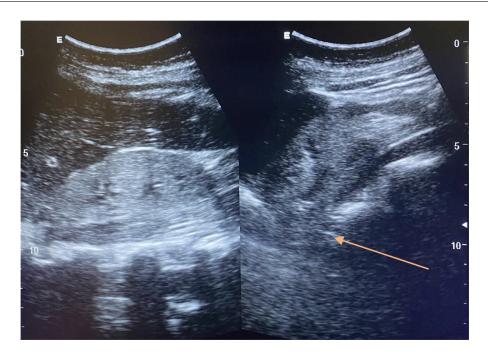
Ultrasonography of both kidneys showing poorly differentiated cortex and medulla (orange arrow).
